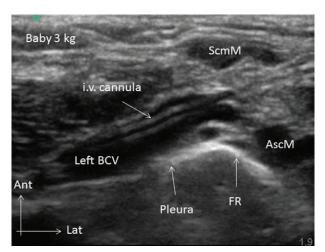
Ultrasonographic long-axis view of the left BCV in a 3-kg infant with the 22-gauge iv cannula clearly inside the vein. Ant = anterior; AscM = anterior scalene muscle; BCV = brachiocephalic vein; FR = first rib; Lat = lateral; ScmM = sternocleidomastoid muscle.
